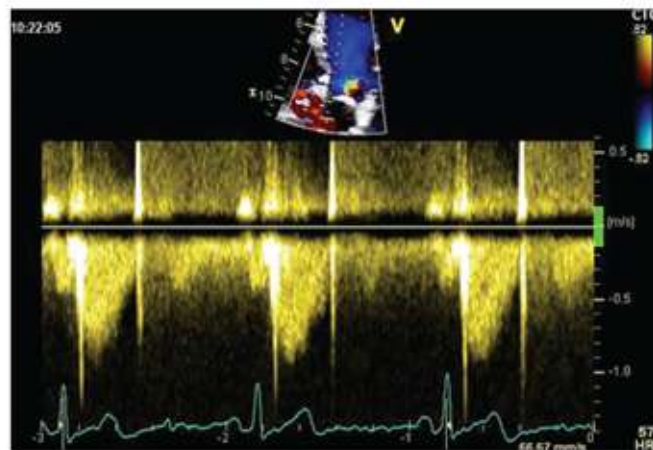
Flow across the aortic valve assessed by continuous-wave Doppler
